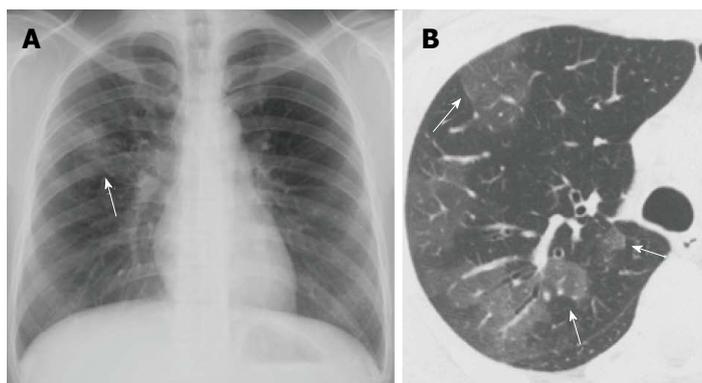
Mycoplasma pneumoniae* pneumonia showing ground-glass opacity predominant pneumonia in a woman in her 30s. A: Chest radiograph shows patchy ground-glass opacity (GGO) with peribronchial nodules in the right middle lung field (arrow); B: Thin-section computed tomography reveals areas of GGO in the right upper lobe. Note that the GGO are partly demarcated by interlobular septa (arrows).
